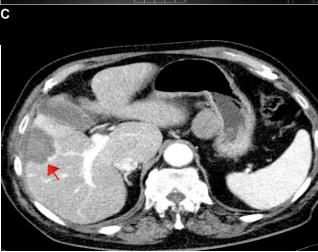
A 83 year old male with history of gastric cancer, was found to have a solitary metastasis of 2.9x2.2x2.4cm in the liver. Pre-procedural CT (A) shows the mass (arrow), which was ablated under US-guidance under general anesthesia. Follow-up CT (B) which was done immediately after the procedure shows good tumor coverage. CT-scan 27 days later (C) reveals ablated mass and no recurrence or other emerging masses.
